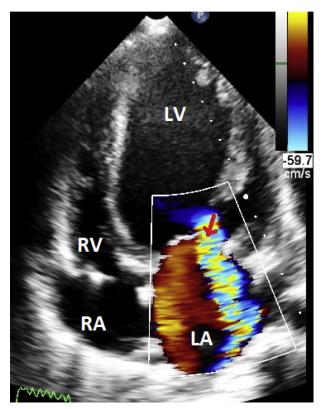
Mitral regurgitation (MR). A 47-year-old woman with ChHD in HF (stage D) and severe MR. The color Doppler image acquired from the apical four-chamber view shows a large eccentric regurgitant color area (*red arrow*) with "wall-hugging" appearance, directed to the left pulmonary veins and reaching the roof of the left atrium (LA), allowing a qualitative visual estimation as severe MR. Regurgitant volume was >50 mL/beat. The left ventricle (LV) is severely hypokinetic and dilated; LVEF was 25%. It is recommended to perform a comprehensive MR evaluation with multiple qualitative and quantitative parameters. *RA*, Right atrium; *RV*, right ventricle.
